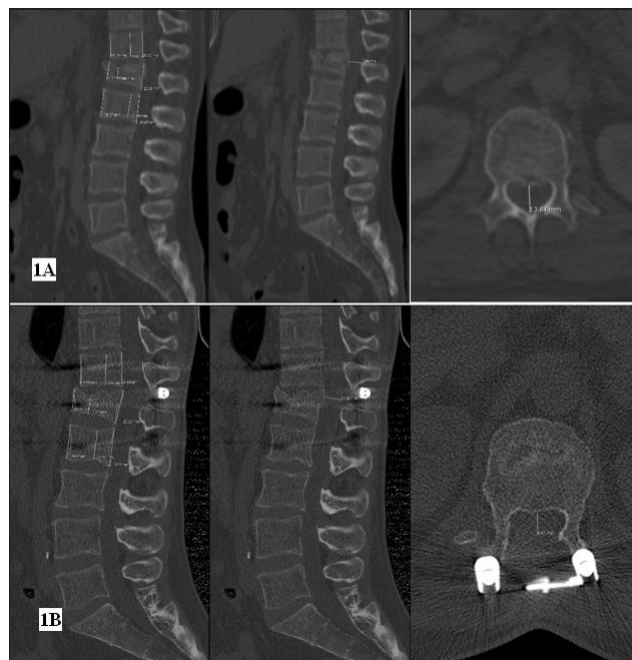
The pictures show the measurement techniques of the anterior, middle, and posterior height loss of the fractured vertebral body (mm), the height loss rate of the fractured vertebra, and the sagittal and axial diameter of the spinal canal (mm) on the preoperative (1A) and postoperative long-term follow-up (1B) CT images of a patient who underwent short-segment instrumentation
